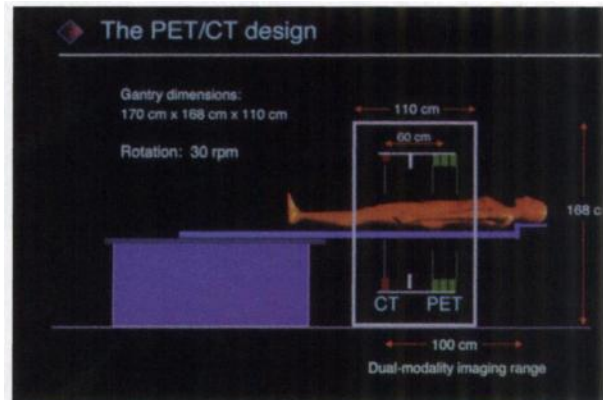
CT and PET scanner mounted on the same gantry so that the patient does not move during the two studies.
